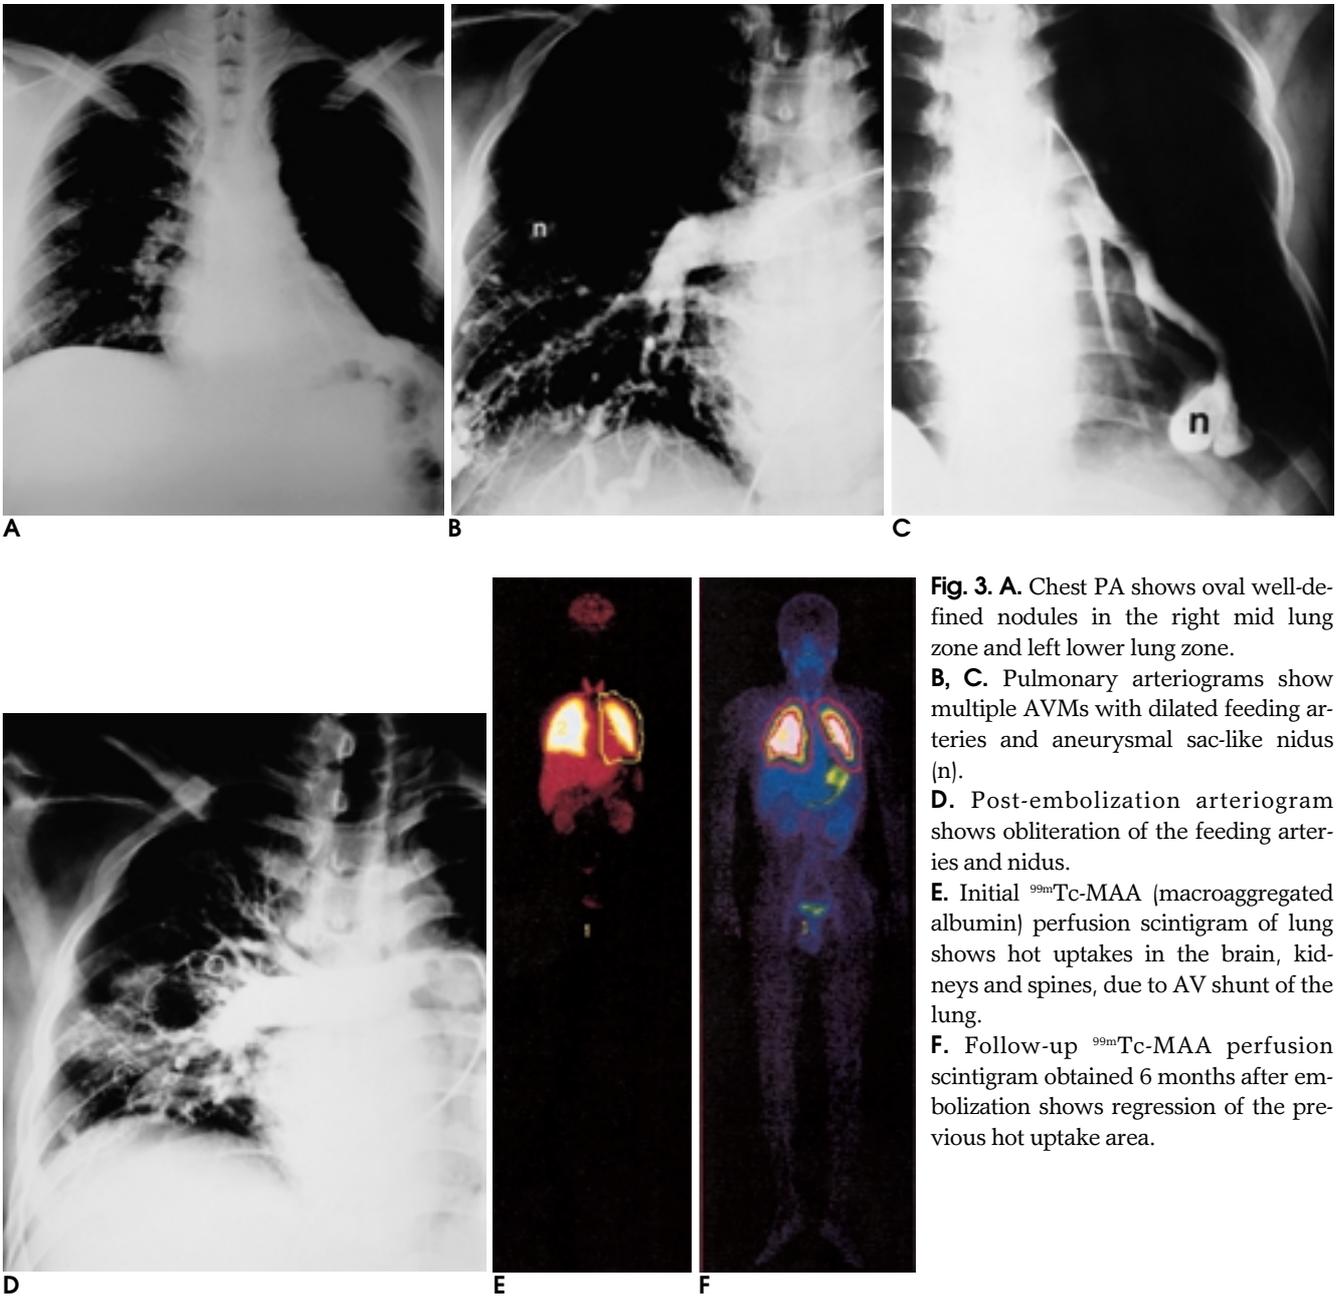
A. Chest PA shows oval well-defined nodules in the right mid lung zone and left lower lung zone. B, C. Pulmonary arteriograms show multiple AVMs with dilated feeding arteries and aneurysmal sac-like nidus (n). D. Post-embolization arteriogram shows obliteration of the feeding arteries and nidus. E. Initial ^{99m}Tc-MAA (macroaggregated albumin) perfusion scintigram of lung shows hot uptakes in the brain, kidneys and spines, due to AV shunt of the lung. F. Follow-up ^{99m}Tc-MAA perfusion scintigram obtained 6 months after embolization shows regression of the previous hot uptake area.
